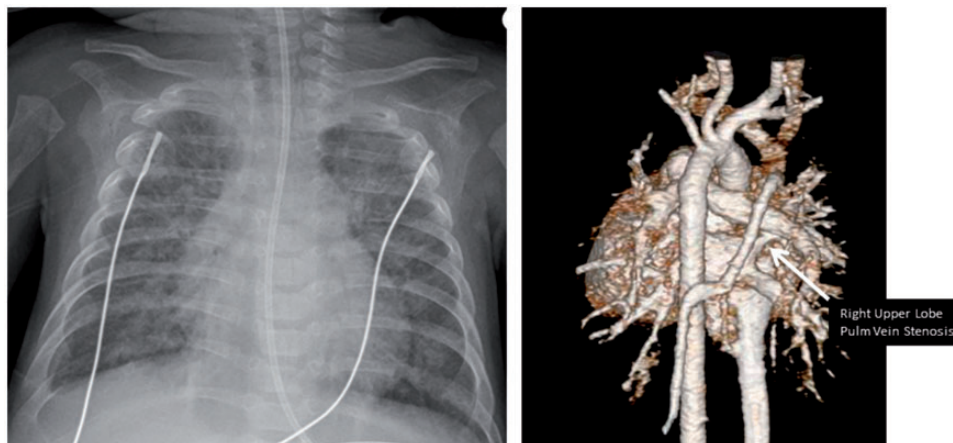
Chest X-ray (left panel) and CT angiography demonstrating pulmonary vein stenosis in an infant with severe bronchopulmonary dysplasia and pulmonary hypertension.
